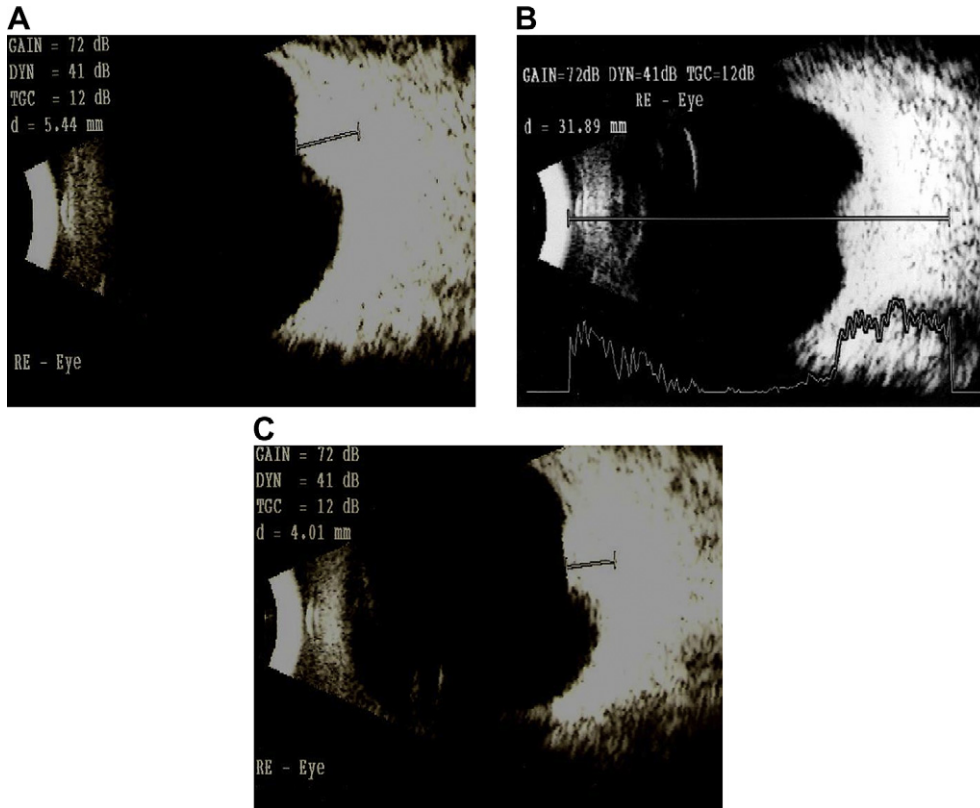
(A) B-scan ultrasound showing an acoustically solid choroid tumor measuring 5.4 mm in height by 11.0 mm in diameter. (B) A-scan ultrasound showing high internal reflectivity within the tumor. (C) B-scan ultrasound performed 1 year after PDT showing that the tumor thickness has decreased to 4.0 mm.
